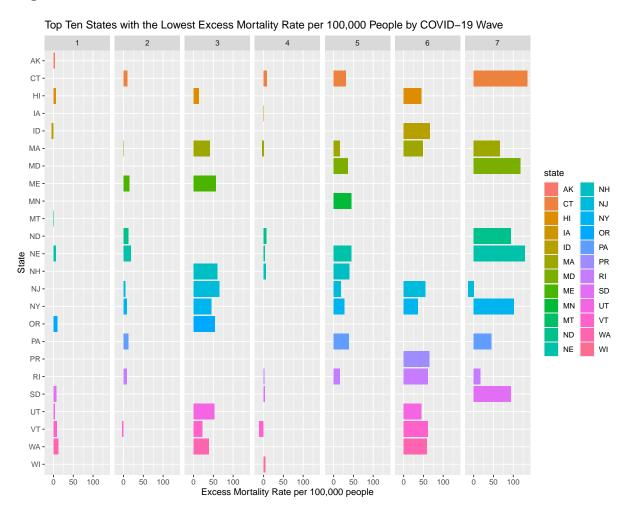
shows that the states with the lowest death rates in the first wave of the pandemic are AK, HI, ID, MT, NE, OR, SD, UT, VT, and WA. All states except for AK and MT remain in at least one subsequent wave, with NE and VT remaining in 4 subsequent waves. The states with the lowest excess mortality rates in the last/ongoing wave of the pandemic (wave 7) are CT, MA, MD, ND, NE, NJ, NY, PA, RI, and SD.
